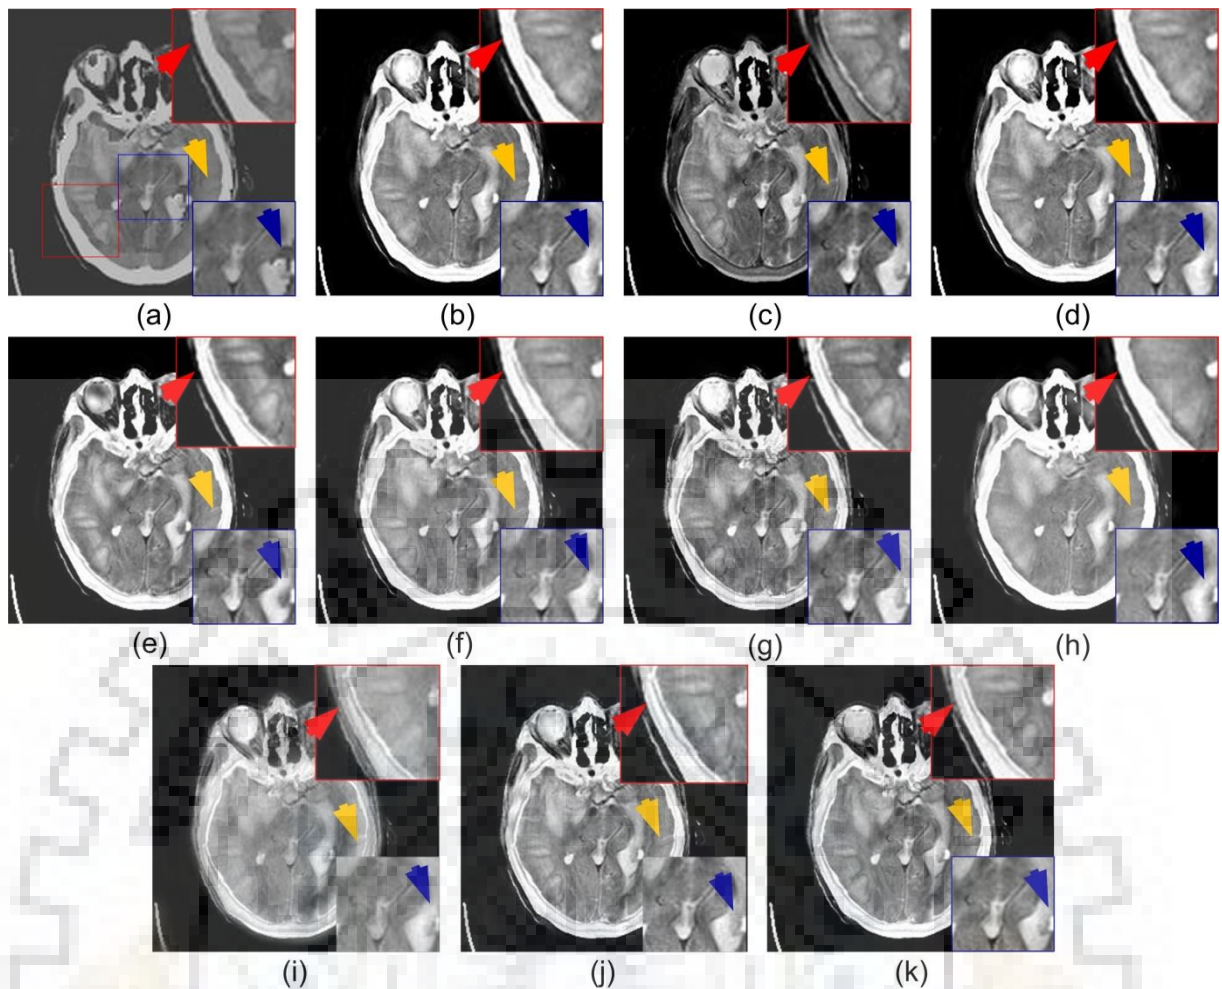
CT-MR image pair-2 shown in Figure 6.5. Comparison of fused images obtained by (a) Nirmla et al., 2016 [137] (b) Das and Kundu, 2012 [34] (c) Li et al. (GFF), 2013 [94] (d) Ganasala and Kumar, 2016 [48] (e) Yang et al., 2017 [203] (f) Zhu et al. (HMSD-GDGF), 2018 [218] (g) Liu et al., 2017 [111] (h) C-MIF method (i) Hermessi et al., 2018 [57] (j) Hou et al., 2019 [59] (k) Proposed CNN-MIF
